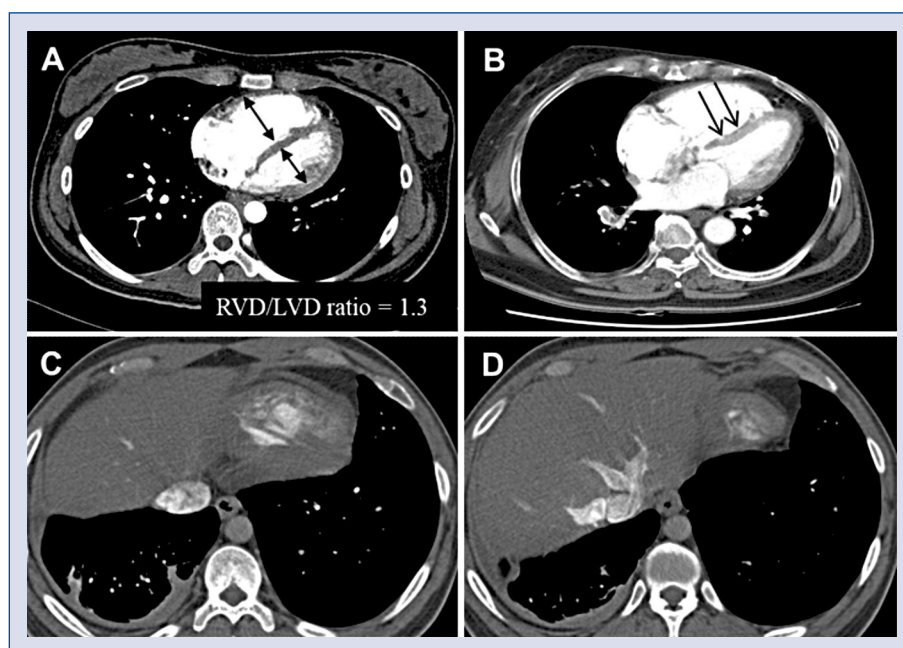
Chest computed tomography angiography suggesting right ventricular (RV) dysfunction. RV dimension is greater than left ventricular dimension (A). Leftward ventricular septal bowing (B). Contrast reflux (arrows) to the inferior vena cava (C) and hepatic veins (D).
